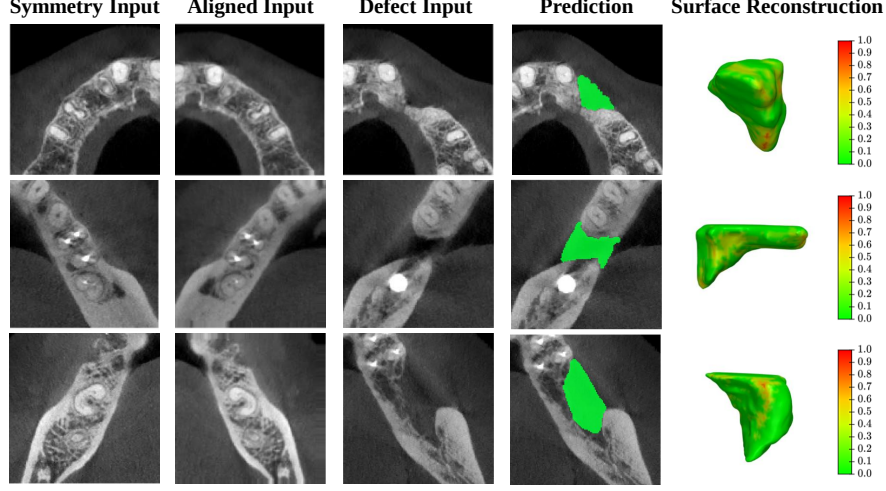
Clinical CBCT reconstruction examples in axial slices. Each row corresponds to a different case. Color maps indicate surface distance errors (mm).
